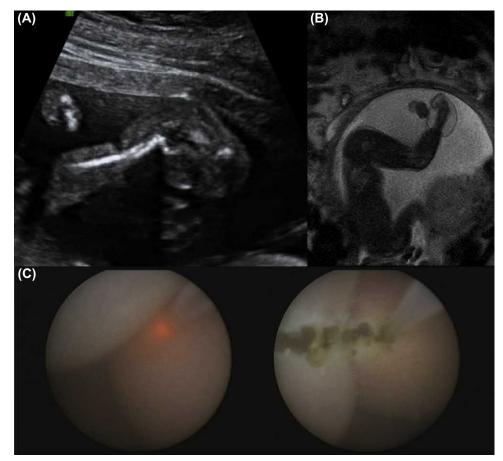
Ultrasound showing severe leg constriction with markedly distal edema and risk of intrauterine amputation (A) Prenatal MRI confirming the ultrasound findings (B) Fetoscopic image of the leg constriction and longitudinal release with a Yag-Laser fiber (C).
